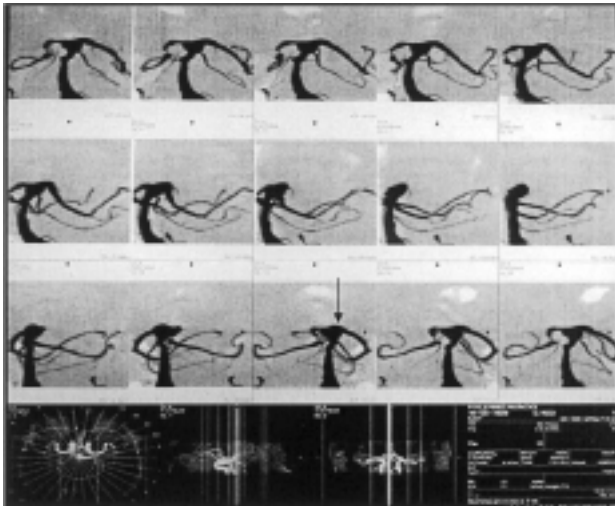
Cerebral magnetic resonance imaging. Note the presence of the cerebral aneurysm located at the apex of the basilar artery, which involved the posterior cerebral and superior cerebellar arteries.
